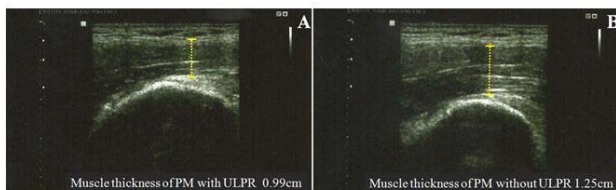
Muscle thicknesses as determined by ultrasound imaging of the cPM muscle during active straight-leg raising in a subject with (A) and without (B) uncontrolled lumbopelvic rotation. PM, psoas major; ULPR, uncontrolled lumbopelvic rotation.
